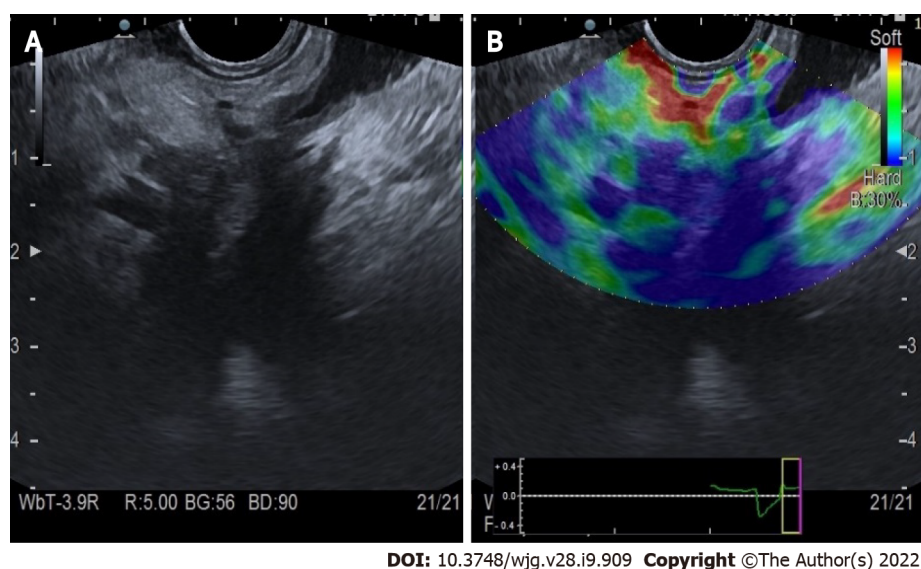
Qualitative endoscopic ultrasound elastography of pancreatic adenocarcinoma of the head. A: Endoscopic ultrasound B-mode; B: Elastographic image.
